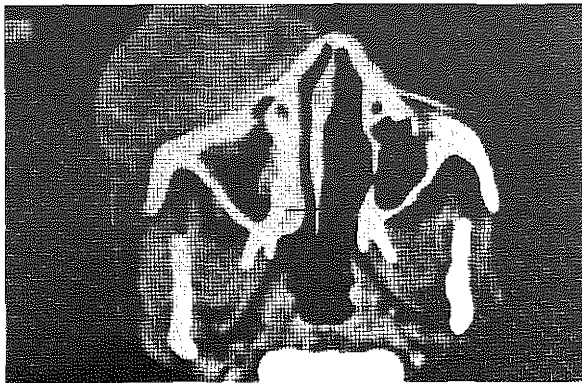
Sagittal CT scan showed no additional finding other than the mass affect of the tumor.
